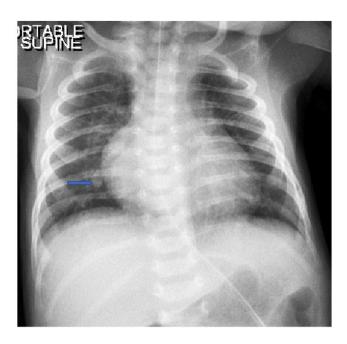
Chest radiograph representing accentuated hilar shadows with prominent vascularity, with small patchy ground glass opacities (GGO) (arrows) mainly Rt basal and parietal with prominent fine linear interstitial shadowing appearance denoting moderate severity of chest involvement in patient with positive PCR for Covid 19 and presenting with moderate clinical manifestation
